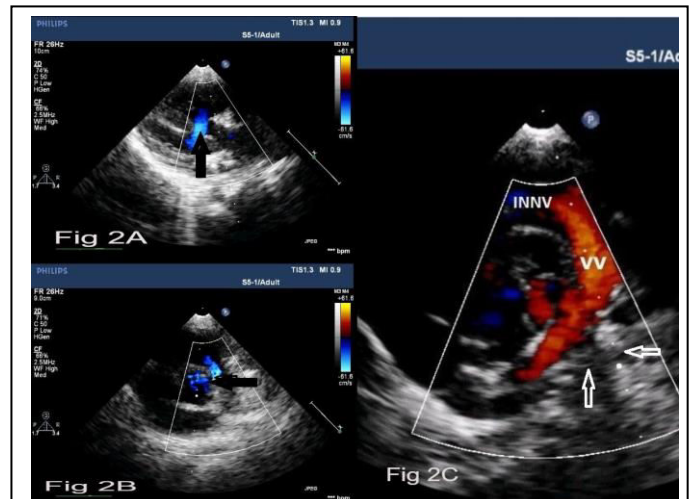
Two-dimensional transthoracic echocardiography showing perimembranous ventricular septal defect (arrow) in parasternal short-axis view (Figure 2A), infundibular stenosis (arrow, Figure 2B), and pulmonary venous confluence (arrows) draining into vertical vein (VV) and Innominate Vein (INN) in suprasternal short-axis view (Figure 2C)
